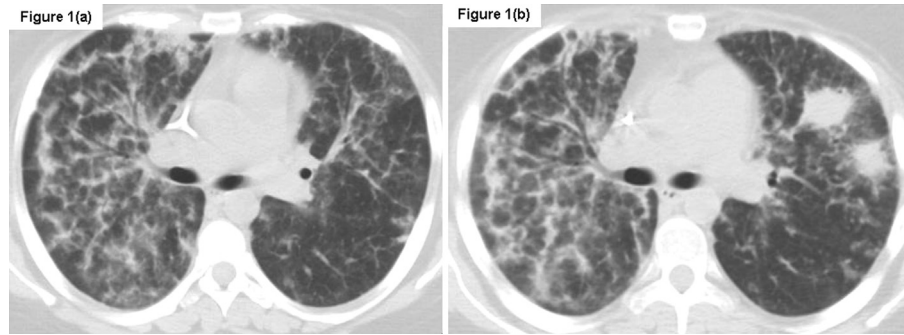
Axial images from Thoracic Computed Tomography (CT) scans acquired in a 32-year old leukaemic patient with Invasive Pulmonary Aspergillosis (IPA). The selected images, which are from identical slice positions, demonstrate bilateral ground glass opacification on Day 21 ((a)) and new intrapulmonary fungal mass lesions, which had developed by the time of repeat scanning on Day 47 ((b)).
